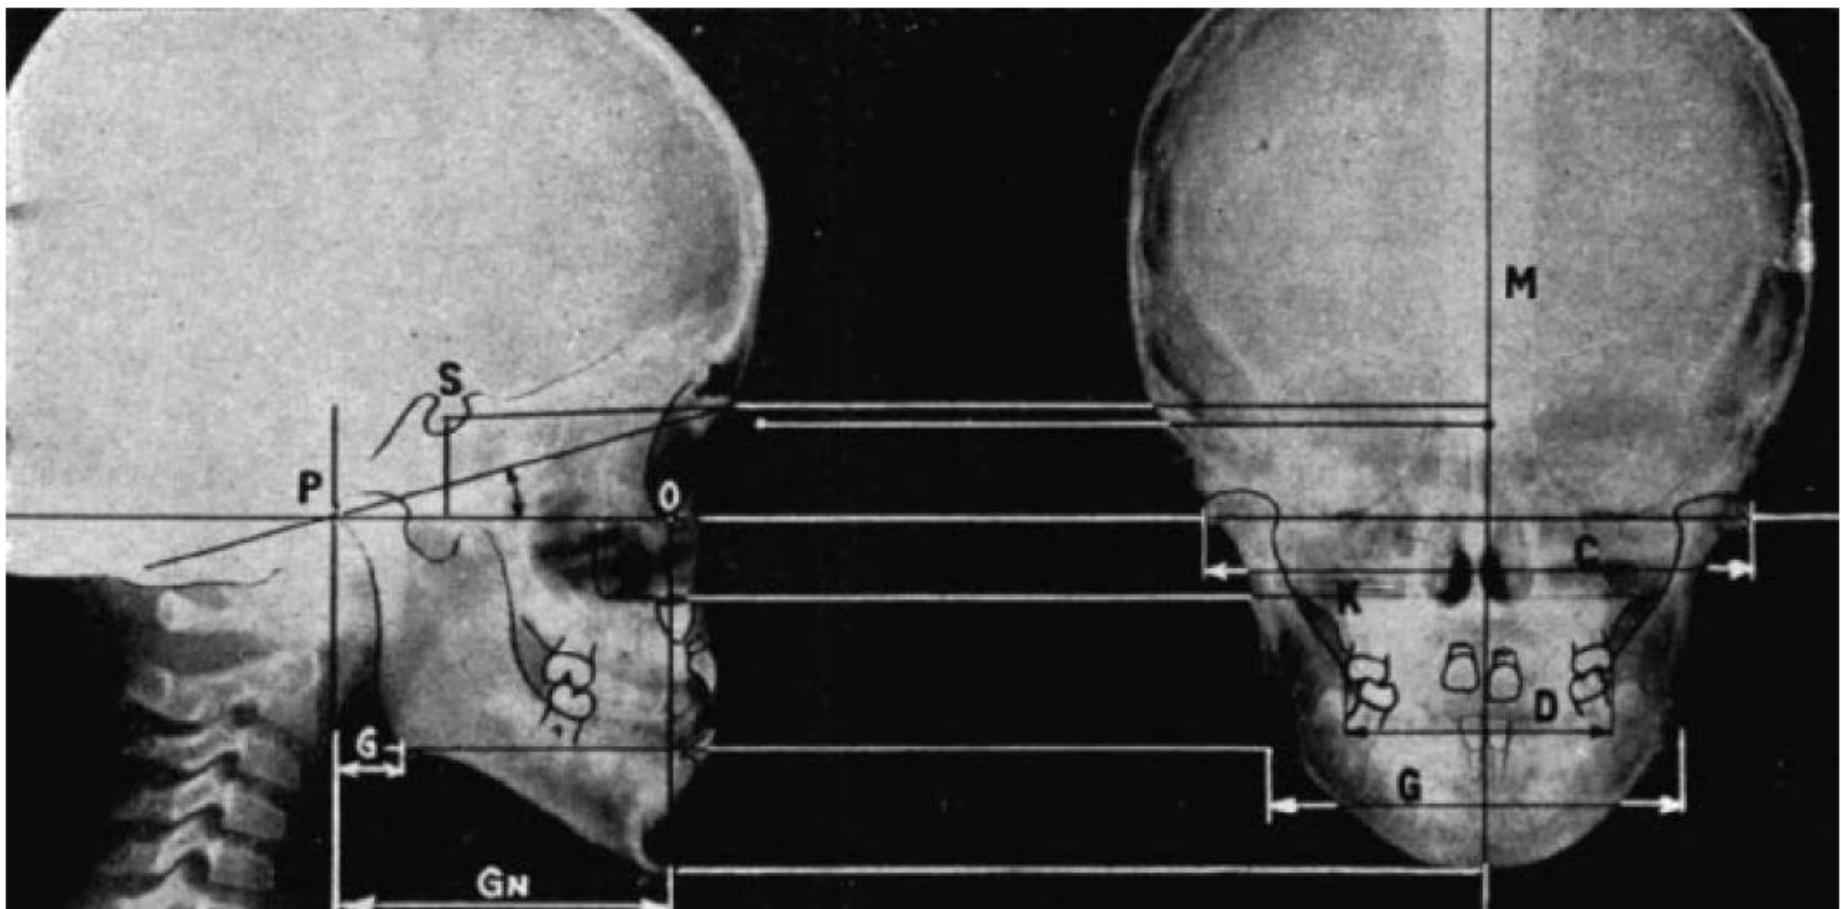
Lateral and Frontal Roentgenograms of a child with a developing Class III mal-occlusion. Note that this craniometric technique applied to the living eliminates the uncertainty of measuring through soft tissue as it is done in cephalometric methods.
